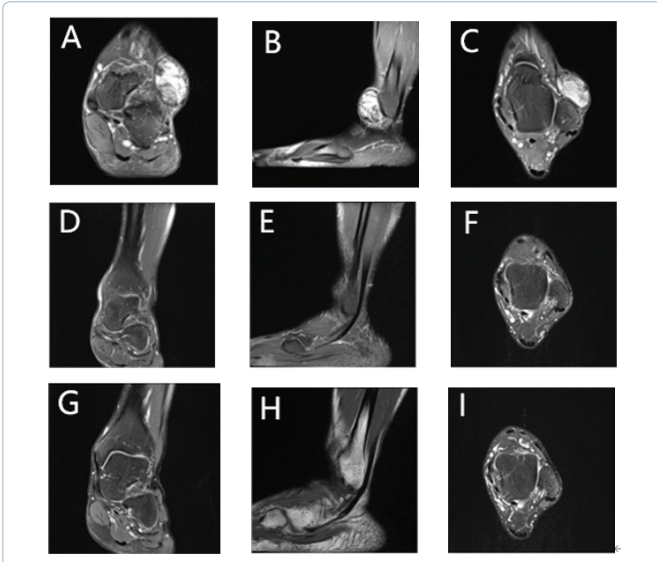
MRI respectively showed imaging characteristics of the preoperative soft-tissue mass on the coronal (A), sagittal (B), and transverse (C) planes. It was completely wrapped by capsule, and there was an enlarging solid component in it, showing uneven hyperintense signals. MRI showed imaging features of the patient's ankle at 6 months (D-F) and 18 months (G-I) postoperatively.
